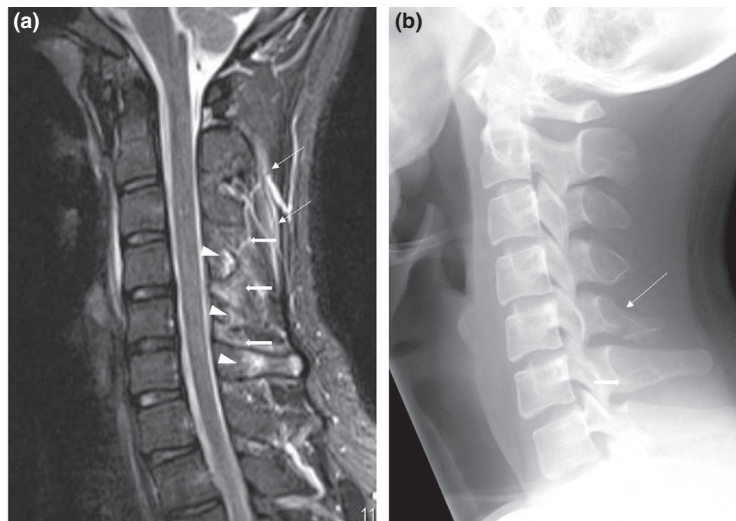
Hyperflexion injury in a 45-year-old man. (a) Mid-sagittal STIR MR images show C4-T1 interspinous (thick white arrows), supraspinous (thin white arrows) ligament tears and C4,5,6 spinous process marrow oedema (white arrowheads). Supraspinous and interspinous ligamentous injuries are usually seen as increased STIR signal but fractures of the posterior elements, widening of the interspinous space and haemorrhage are clues to more severe/ complete tears. (b) Lateral radiograph confirms a slightly displaced C5 spinous process fracture (arrow). The C4 and C6 spinous process changes on MRI are likely to be due to bone bruises. Injuries to the posterior ligamentous complex of Holdsworth (ligamentum flavum, interspinous, supraspinous ligaments and the facet joint capsules) are usually accompanied by fractures of the posterior elements.
